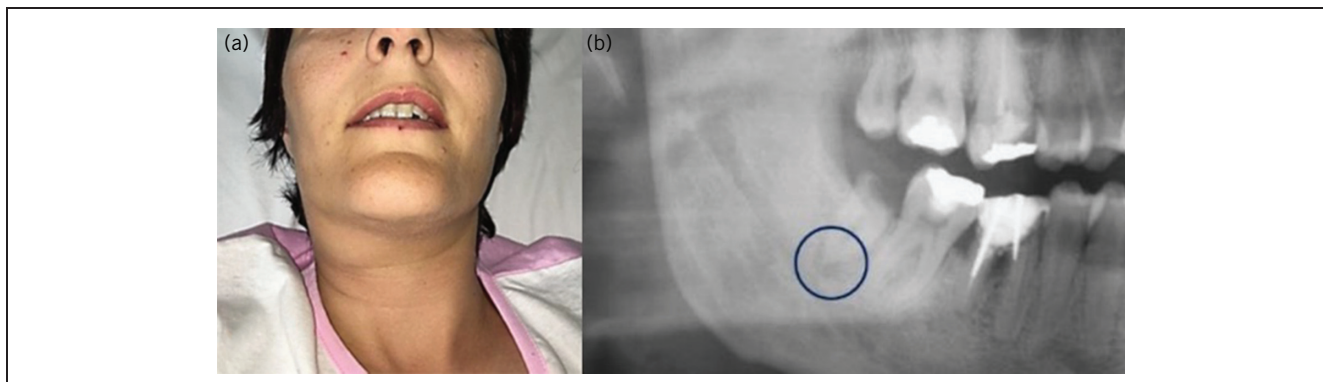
Extra oral (A) clinical presentation of the patient at admission. (B) Pretreatment panoramic radiograph showing the causative tooth.
